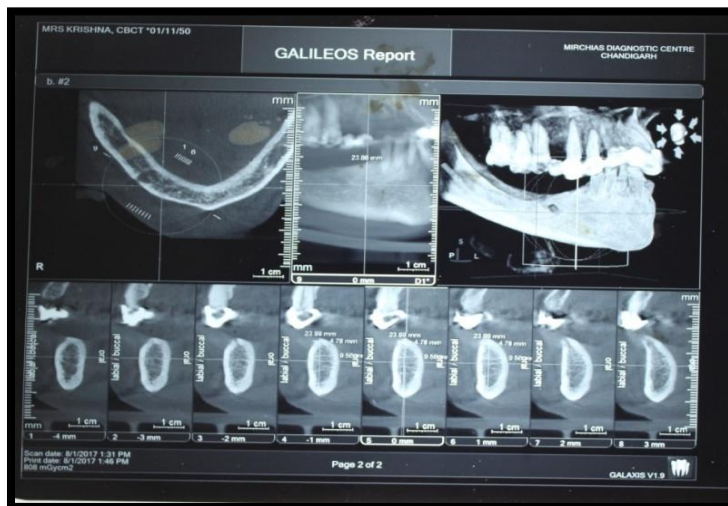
Pre operative CBCT image with slicings at 1mm distance - left side of the mandible
